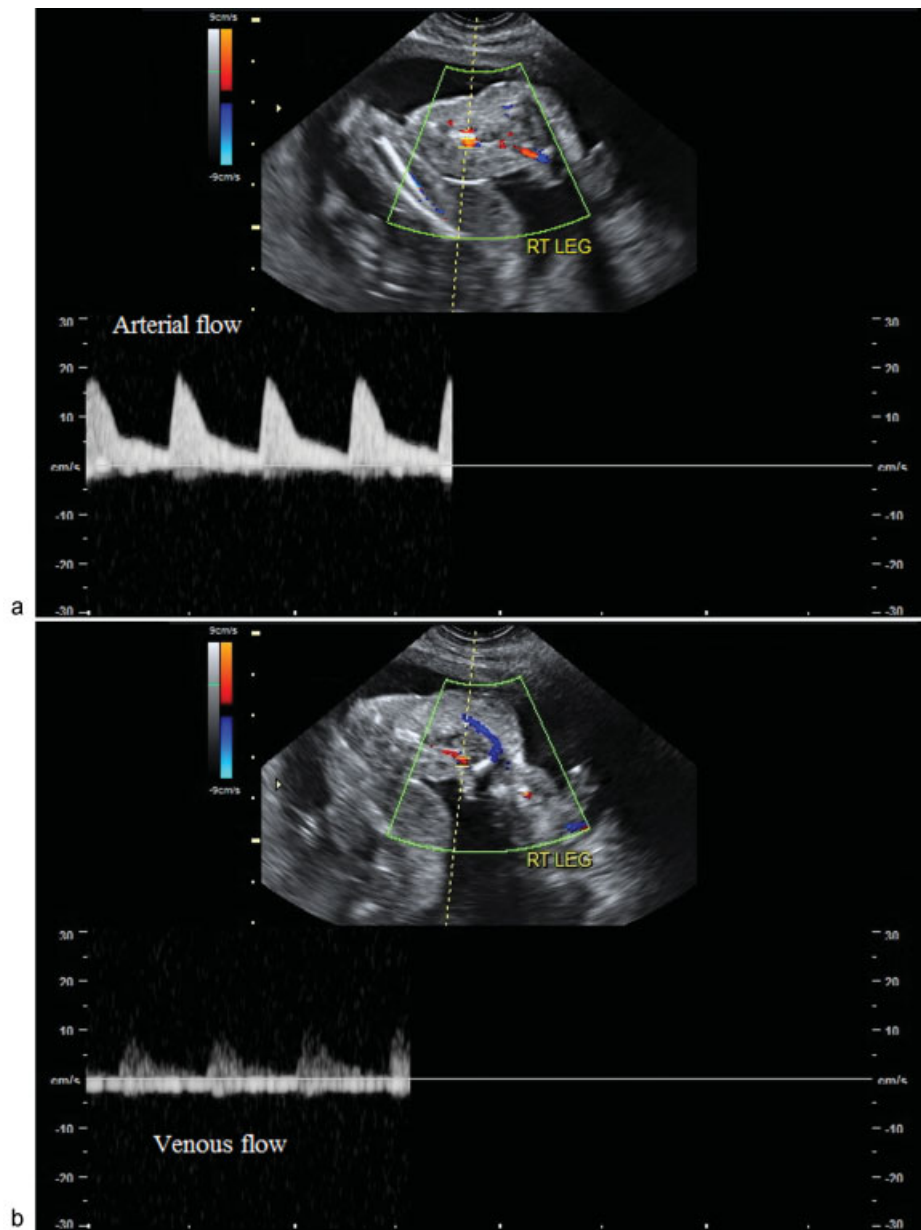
Postoperative ultrasound images of the right lower extremity demonstrating both arterial (a) and venous (b) color Doppler waveforms distal to the constriction site.
